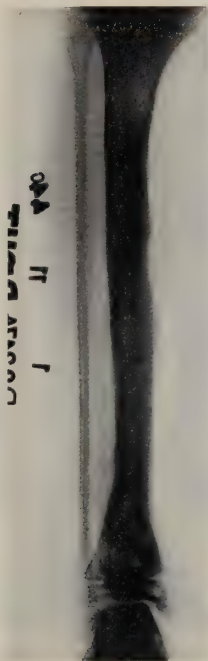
X-ray showing restitution two years and three months after operation.
